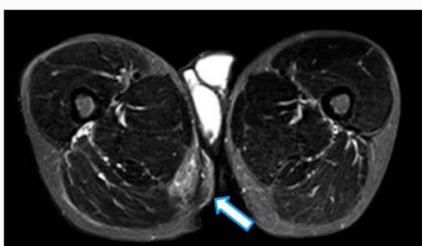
Fluid sequence axial MRI image enhancing the tissue edema associated with the benign perineal pseudotumor in the right perineum.
